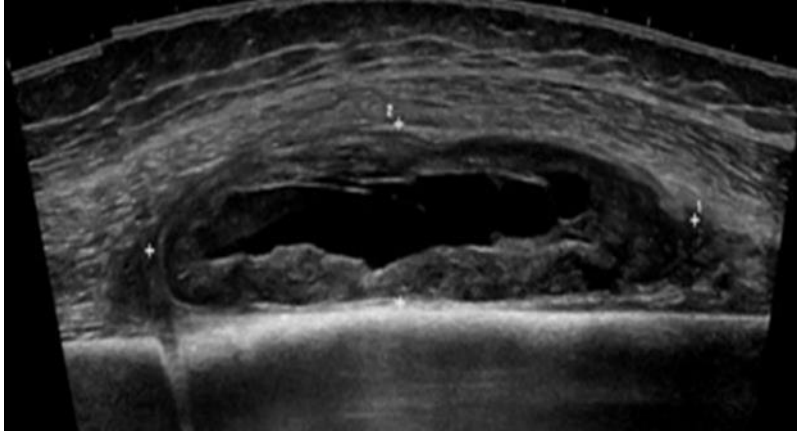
UPS of the thigh. Longitudinal panoramic ultrasound of a deep soft tissue mass in the thigh demonstrates a heterogeneous solid mass with a hypoechoic center. This represents hemorrhage/necrosis [28].
